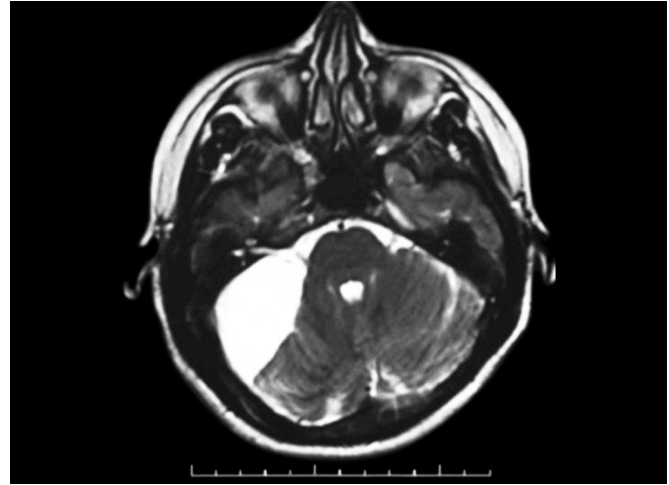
Arachnoid cyst. Axial T1-weighted magnetic resonance imaging (MRI) of a large cerebellopontine angle (CPA) arachnoid cyst with characteristic hyperintensity matching the signal intensity of cerebrospinal fluid (CSF).
